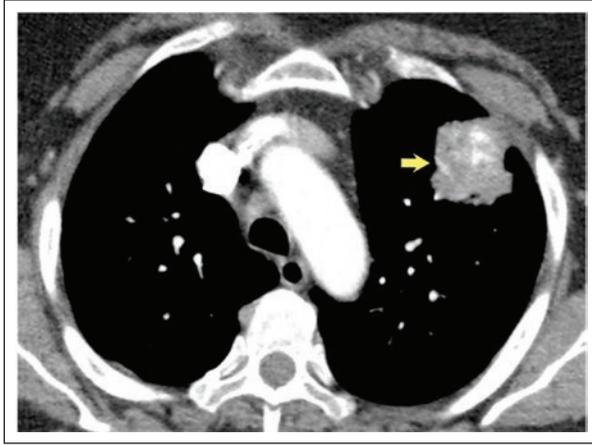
Amyloidoma. Chest CT, axial view, showing subpleural mass in the left upper lobe, solid, irregular contour, with calcifications (arrow).
